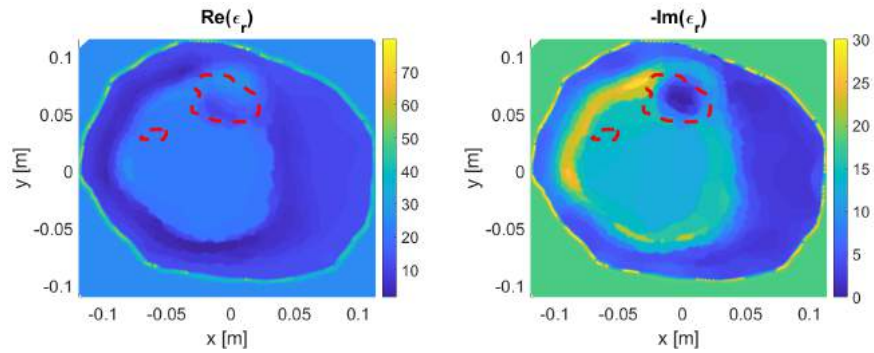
Varying imaging domain to enhance MRI model 2 reconstruction.
